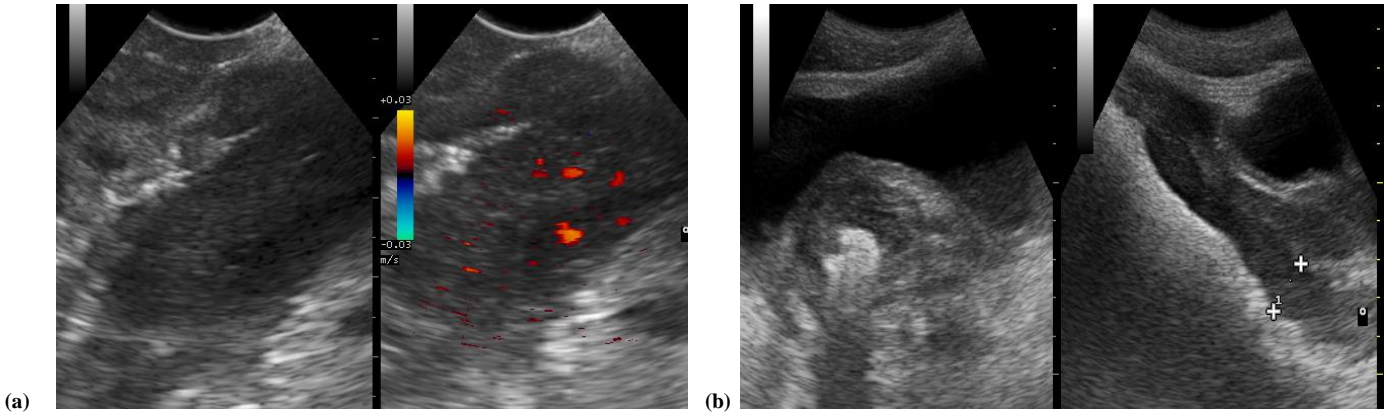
(a): Endorectal sonography b-mode and color Doppler and figure1 (b): Transabdominal USG: Patient with rectosigmoid mass show marked circumferential thickening of wall of rectum and sigmoid colon with abnormal increase vascularity.
